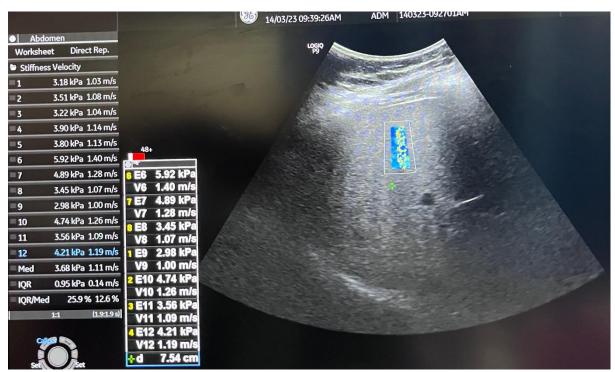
2-D Shear Wave Elastography : Elasticity: 3.68 kPa, corresponding to F0-F1 grade (Normal) in a 51 year old female patient who came for a routine abdomen sonogram and was found to have fatty liver grade 2. Her Liver function tests and biochemical markers (AST : 44 U/L; ALT : 37 U/L; AAR: 1.1; APRI : 0.42; FIB-4 : 1.65; ALP: 63 U/L; GGT: 21 U/L; Platelet Count: 223 x $10^3 \mu$ L; Total Serum Bilirubin : 1.7 mg/dL; Serum Albumin : 4.8 g/dL) were within normal limits which corresponded with the elasticity measurements.
